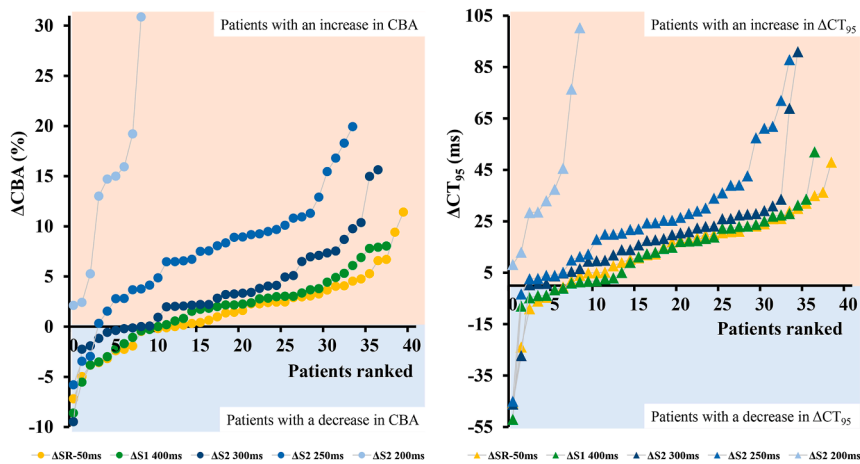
Differences in prevalence of CBA prevalence (left panel) and CBA severity (right panel) between SR and the various PES protocols are plotted for each individual patient. Patients are ranked according to increasing differences in CBA or CT₉₅. A positive or negative change in CB (severity) is indicated by respectively an orange or blue background. CBA = conduction block area; CT = conduction time; PES = programmed electrical stimulation; SR = sinus rhythm.
